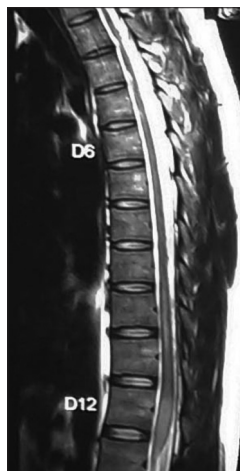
Magnetic resonance imaging of dorsal spine showing central T2 hyperintensities of the cord
